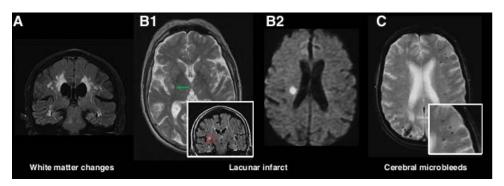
MRI manifestations of cerebral small vessel disease (Charidimou & Werring, 2012).
